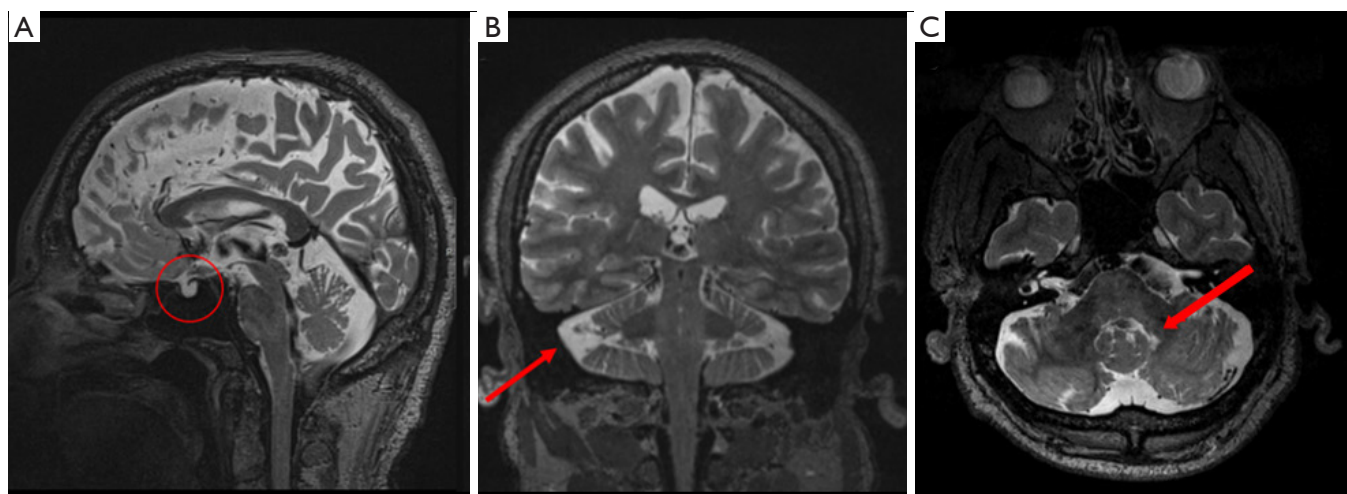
Brain MRI findings in Erdheim-Chester disease (ECD). (A) The red circle shows the empty sella (ES), with the sella occupied by a cerebrospinal fluid diverticulum; (B) Enlargement of cerebellar subarachnoid spaces was highlighted (red arrow); (C) Volumetric sequence T2-weighted showing an hyperintense signal alteration around the 4th ventricle on axial plane, mainly on the left side (red arrow).
